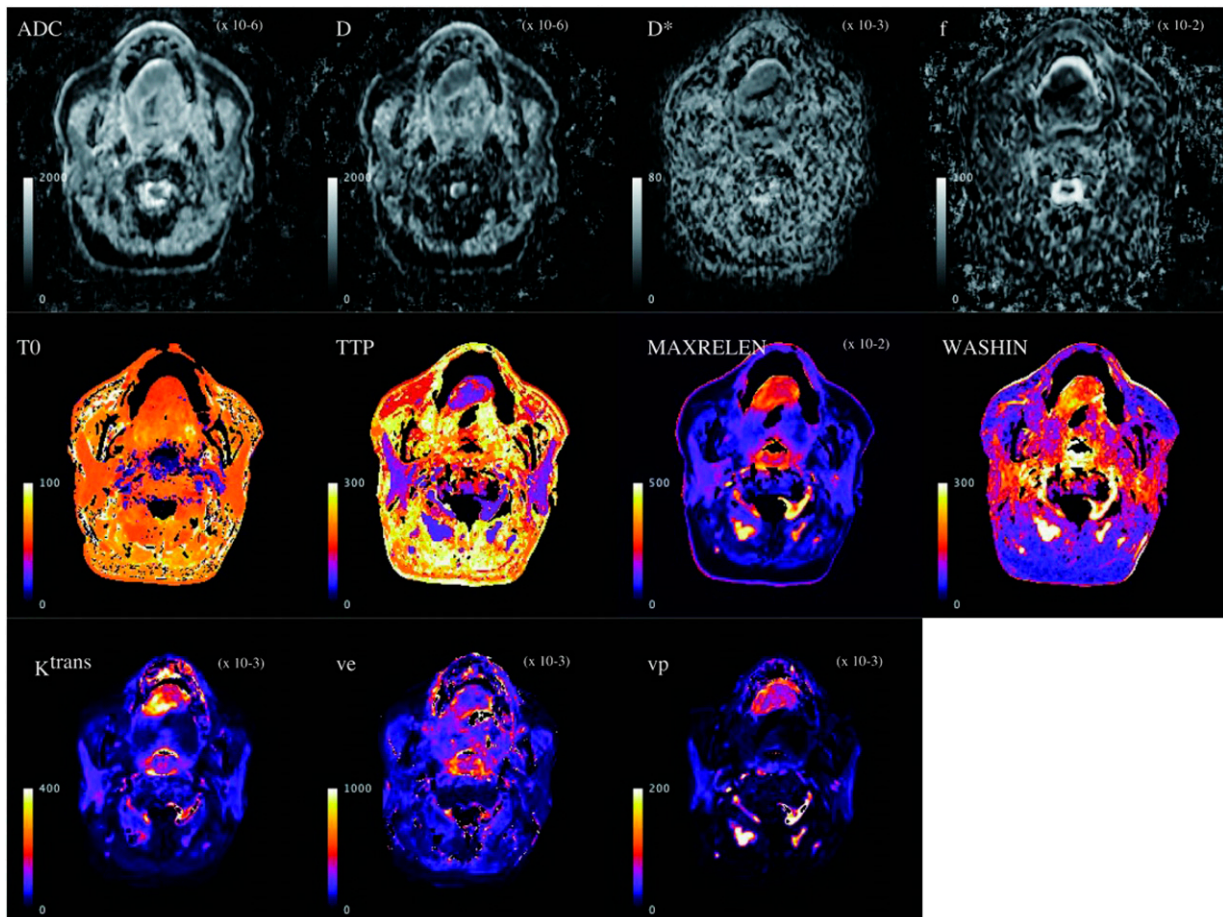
A 70-year-old woman with salivary duct carcinoma at the tongue. The ADC, D, D* and f were obtained by TSE-DWI. This lesion had ADC, D, D*, and f values of $1.06 \times 10^{-3} \text{ mm}^2/\text{s}$, $0.772 \times 10^{-3} \text{ mm}^2/\text{s}$, $32.5 \times 10^{-3} \text{ mm}^2/\text{s}$ and 0.31, respectively. The T₀, TTP, MAXRELENH and WASHIN were obtained by a T₁ perfusion analysis. This lesion had T₀, TTP, MAXRELENH, and WASHIN values of 51.1 s, 86.4 s, 2.35 and 180, respectively. The K^{trans} , ve and vp were obtained by a TK model analysis. K^{trans} was 0.226 min^{-1} , ve was 0.252 and vp was 0.068. High perfusion-related parameters (f, K^{trans} and vp) and low D values were characteristic of this lesion.
